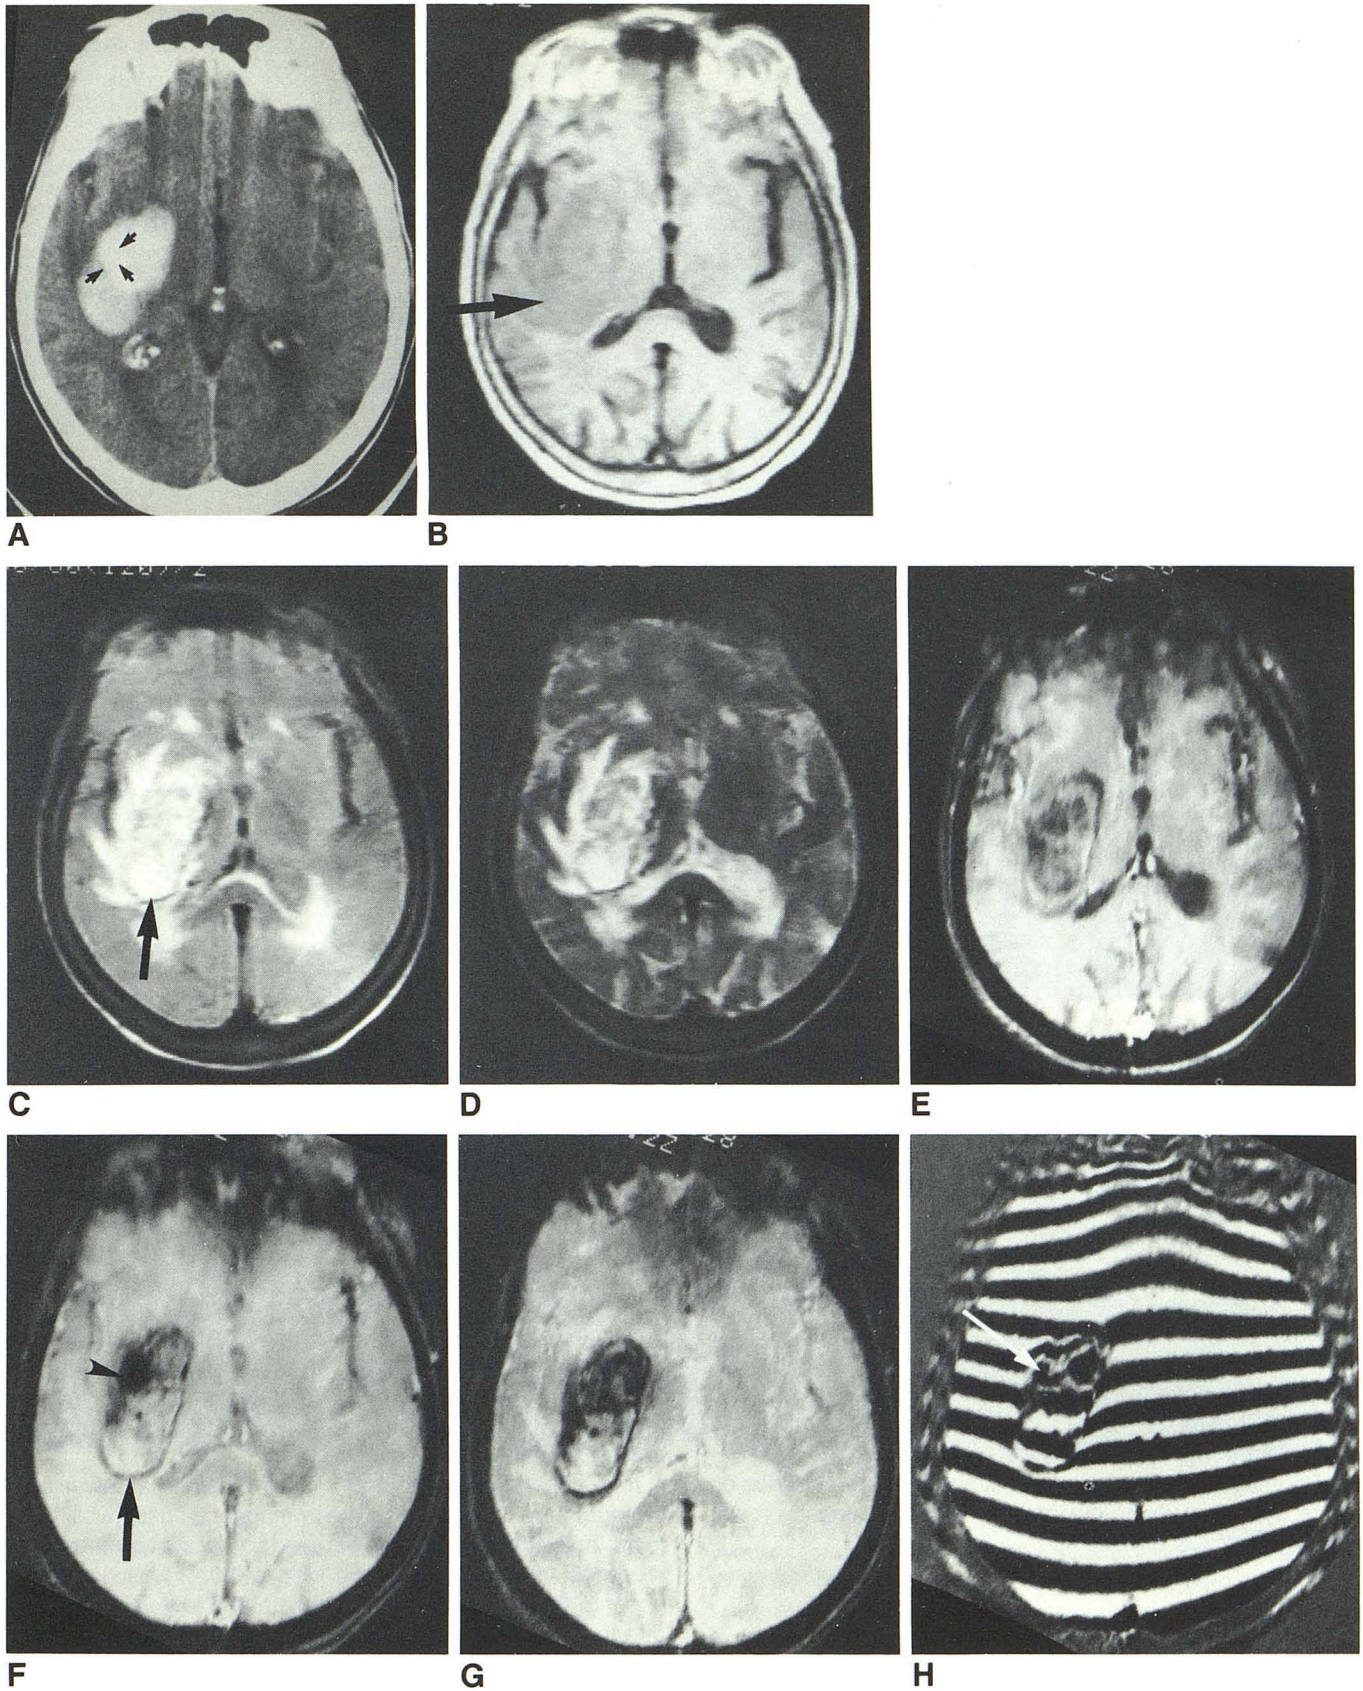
Patient with acute right putaminal hemorrhage. A, CT scan done shortly before MR examination shows hyperdense hemorrhage with more focal region (arrows) measuring 9 H higher attenuation than rest of hemorrhage. B, T1-weighted SE image shows nonspecific lesion (arrow) isointense to gray matter. C, T2-weighted SE image (TE = 60 msec) shows hyperintense lesion. There is a suggestion of a low-intensity halo (arrow). Mild central hypointense area is similar in intensity to white matter. Findings raise possibility of hemorrhage. D, More T2-weighted SE image (TE = 120 msec) shows similar findings to B. E, T1-weighted PS image (TE = 16 msec) shows hypointensity within lesion, in contrast to A. Note marked degree of flow enhancement compared
